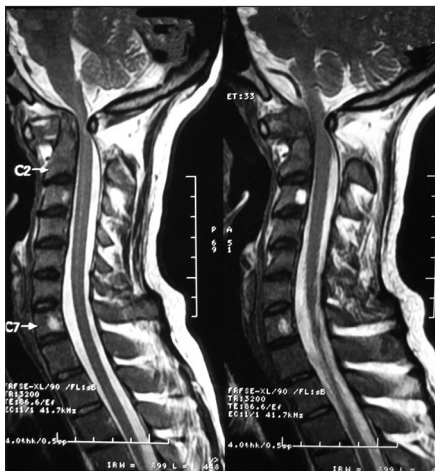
MRI showing severe narrowing at CVJ
